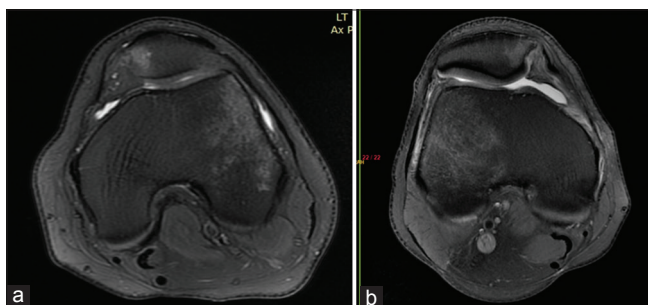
(a) Axial PDFS MR image of knee joint showing classical pattern of bone marrow edema involving medial patella and lateral femoral condyle with wavy medial patellar retinaculum. (b) Axial PDFS MRI knee image of another patient showing bone marrow edema in medial patella and lateral femoral condyle with medial patellar retinaculum and MPFL injury
